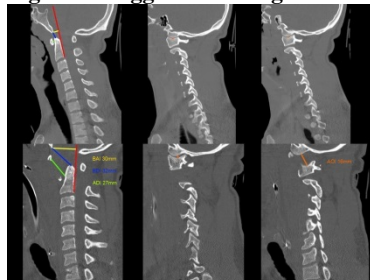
Medial, right and left sagittal Cervical CT images with annotations depicting the posterior axial line (red), Basion-Axial Interval (yellow), Basion-Dens Interval (blue), Atlanto-Dental Interval (green) and Atlanto-Occipital Interval (orange). Normal comparison images above, case images below.
